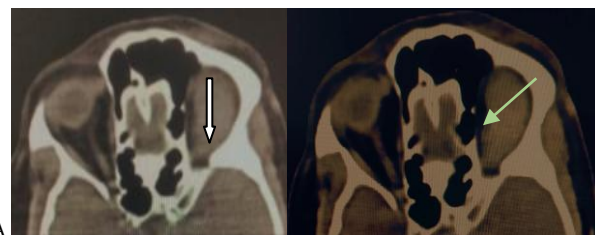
Pre-contrast (A) axial image on CT scan of orbit shows a lobulated soft tissue density mass (thick arrow) at extraconal compartment of left orbit. Post contrast (B) scan shows almost homogeneous enhancement of the mass (thin arrow).
